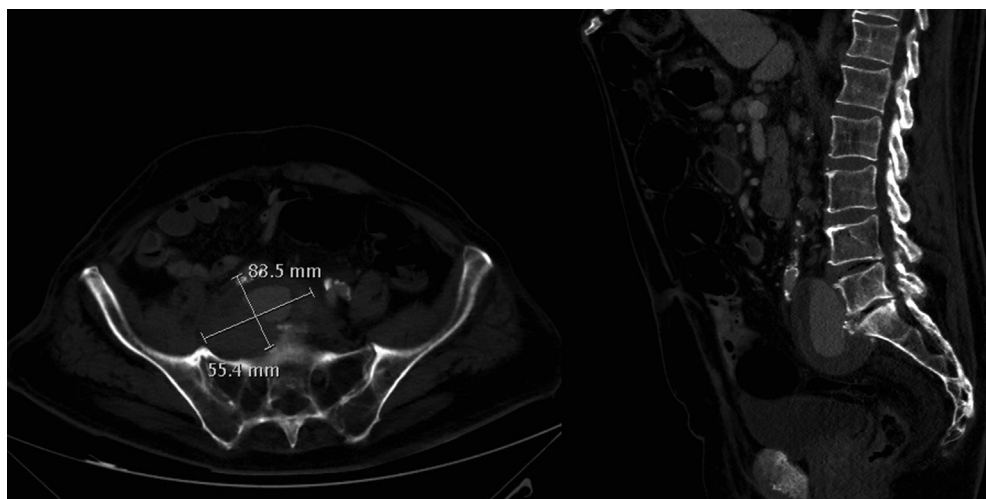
Computed tomography angiography image demonstrating the median sacral artery pseudoaneurysm in transverse and sagittal views with extension into the psoas muscle.
